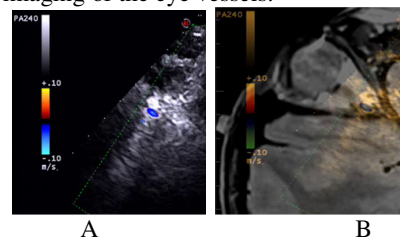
A) CD signal of the ophthalmic vein; B) VN MRI and US fusion: ophthalmic vein CD signal.
